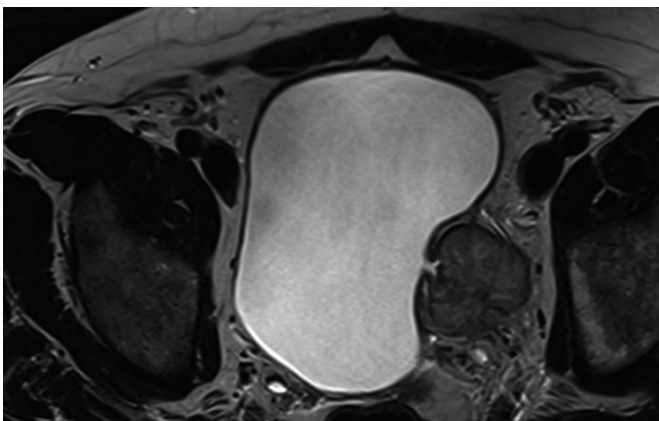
Axial T2-weighted magnetic imaging shows a solid lesion, with lobulated contour, intermediate T2 signal intensity and a small central indentation
